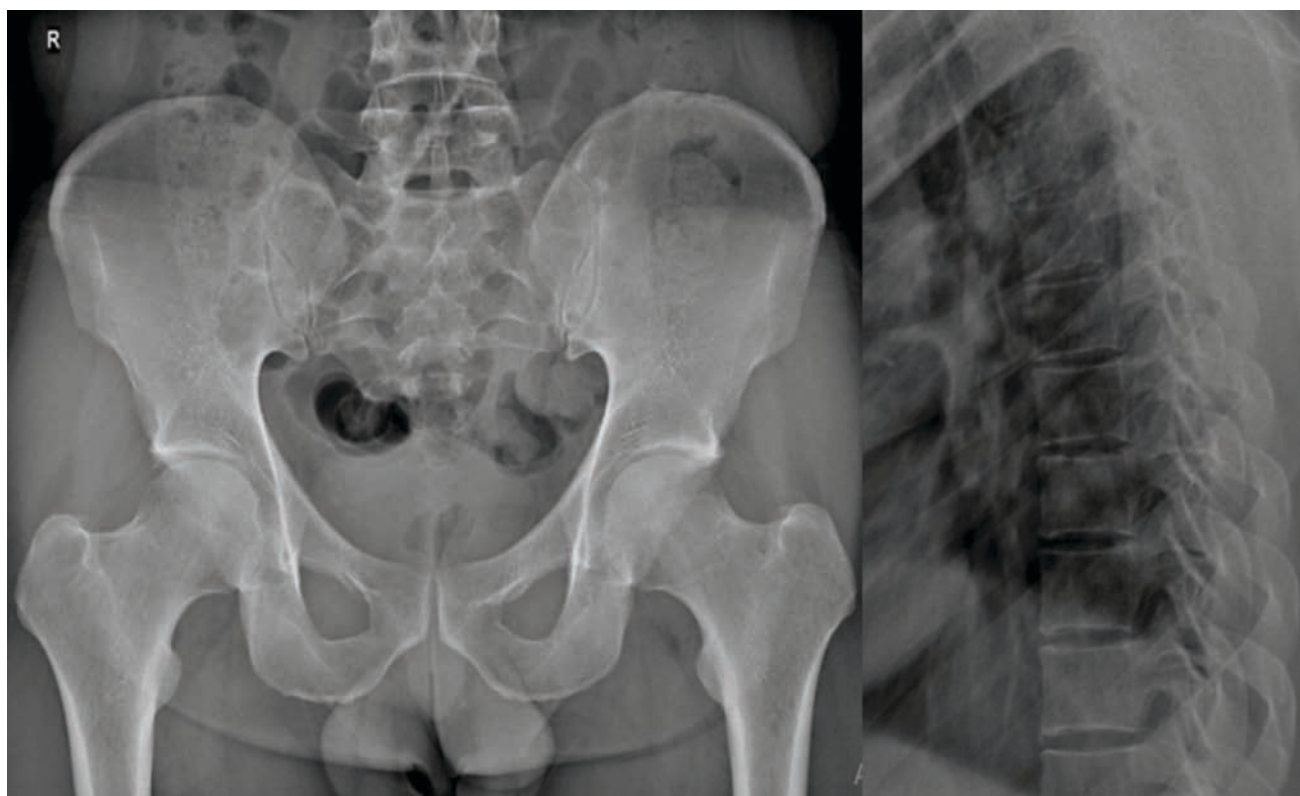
Plain X-ray of the pelvis and spine showing minimal acetabular sclerosis
